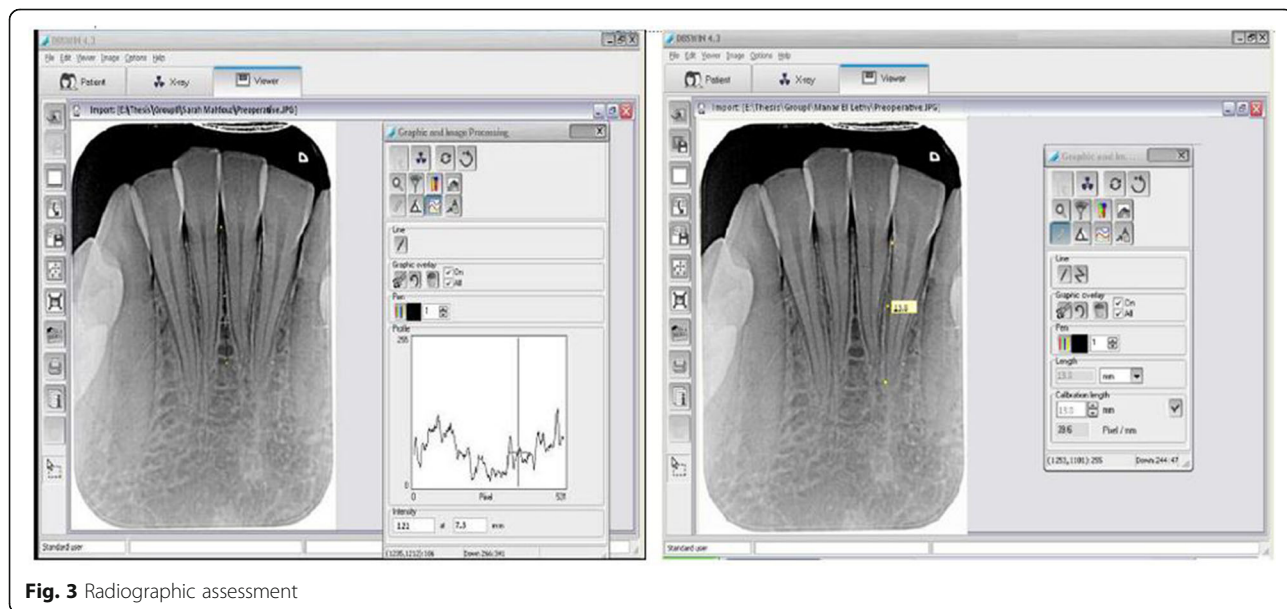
Radiographic assessment
